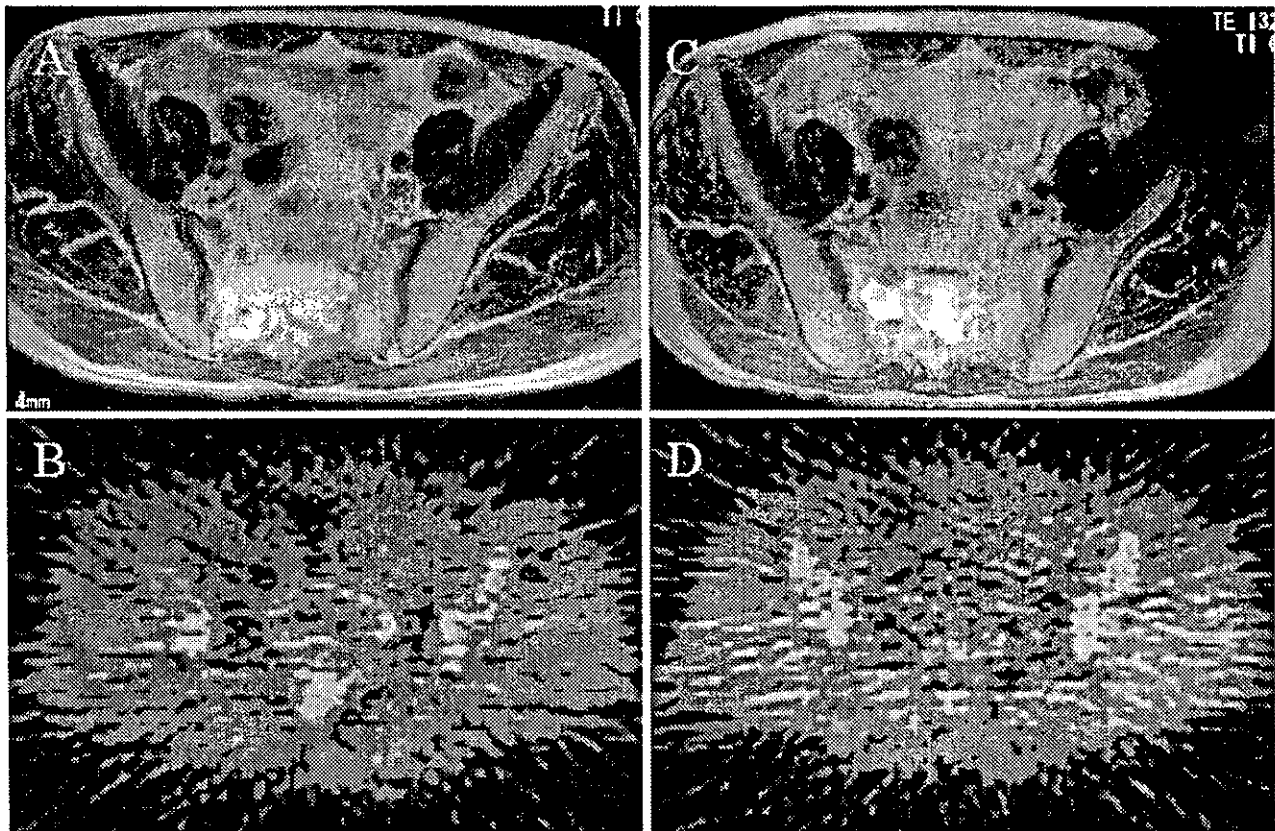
Case 8. A 65-year-old man who received 73.6 GyE to chordoma in the sacrum. A, C MR images showed a large mass at the sacrum before (A) and after CIRT (C). B, D However, no
